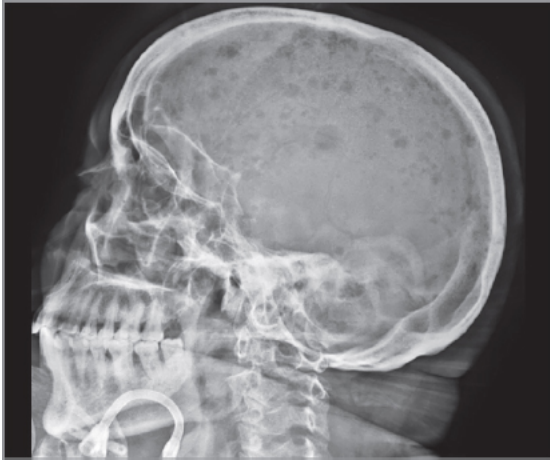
Lateral X-ray of skull showing multiple punched out lesions.
